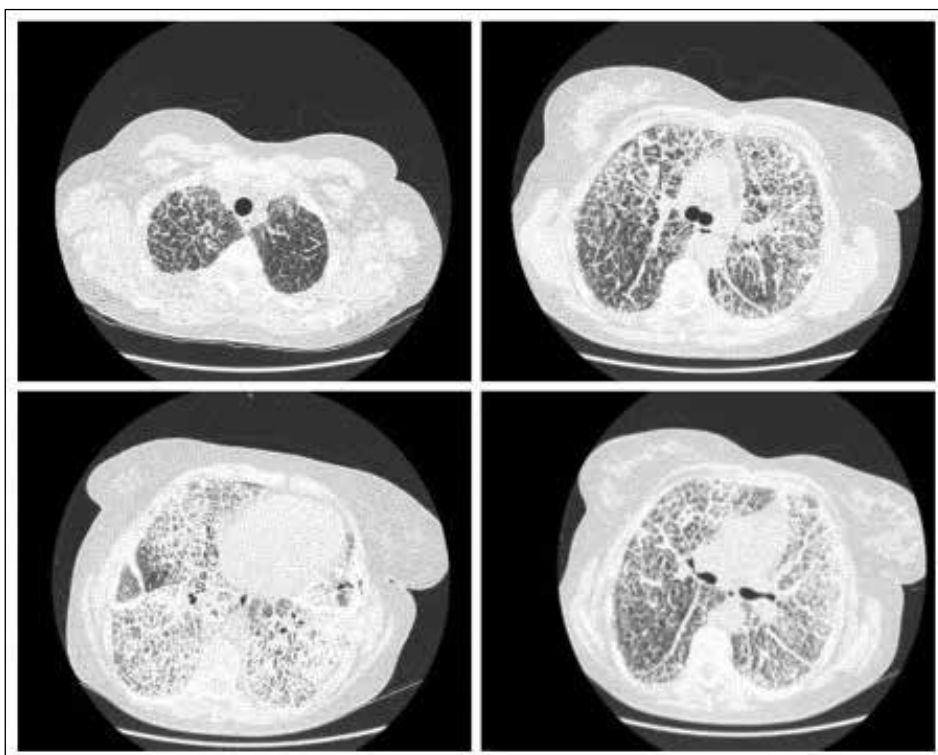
Chest CT. Lung window.
